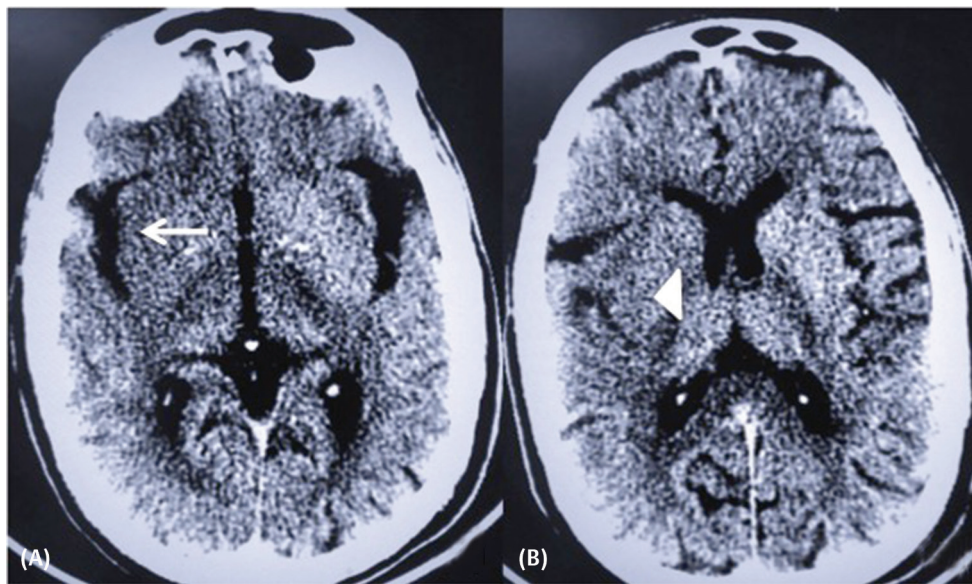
Axial noncontrast computed tomography (CT) brain sections demonstrating the two early signs of stroke corresponding to loss of gray–white matter definition, namely loss of “insular ribbon” sign (arrow, A) and “obscure lentiform nucleus” sign (arrowhead, B). Note the normal attenuation of similar structures of the contralateral side.
